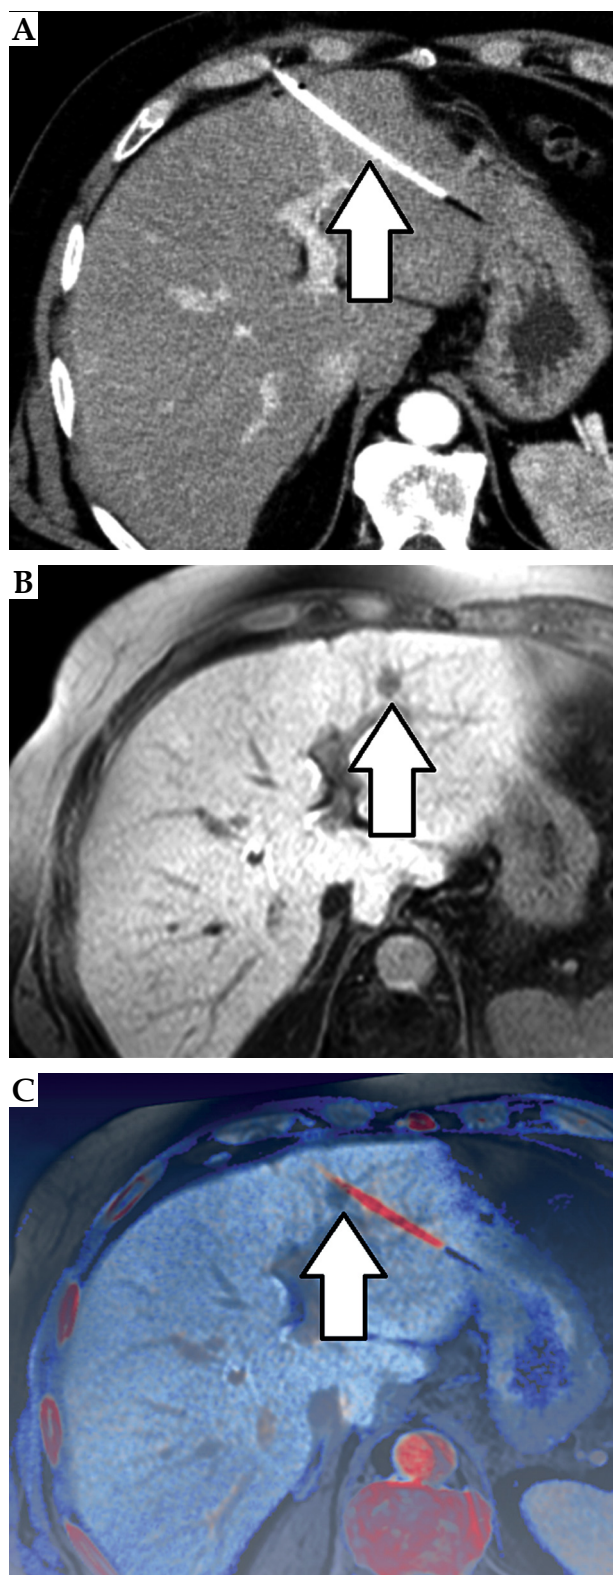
Image fusion data set: peri-interventional CT showing HDR brachytherapy catheter (arrow, A), follow-up MRI suspecting a needle track lesion (arrow, B), axial image fusion of follow-up MRI and planning CT of HDR brachytherapy confirming the origin of the new lesion within the former path of the brachytherapy catheter (arrow, C)
